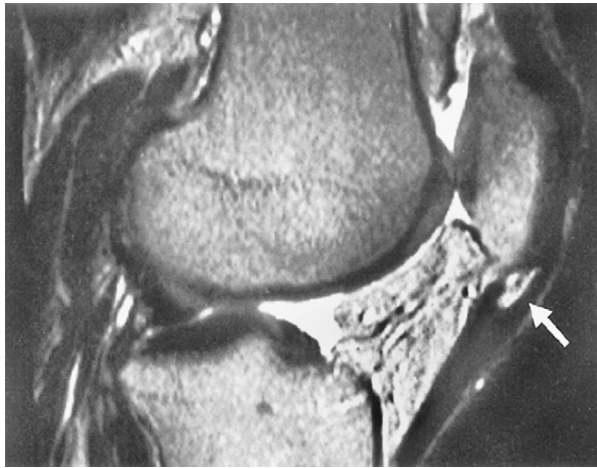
Magnetic resonance imaging scan of a patient with jumper's knee (patellar tendinopathy), demonstrating the classic location of the lesion (arrow) associated with this condition. (Reprinted with permission from Lavignino M, Armoczkly SP, Elvin N, Dodds J. Patellar tendon strain is increased at the site of jumper's knee lesion during knee flexion and tendon loading. *Am J Sports Med* 36(11):2110–2114, 2008.)
